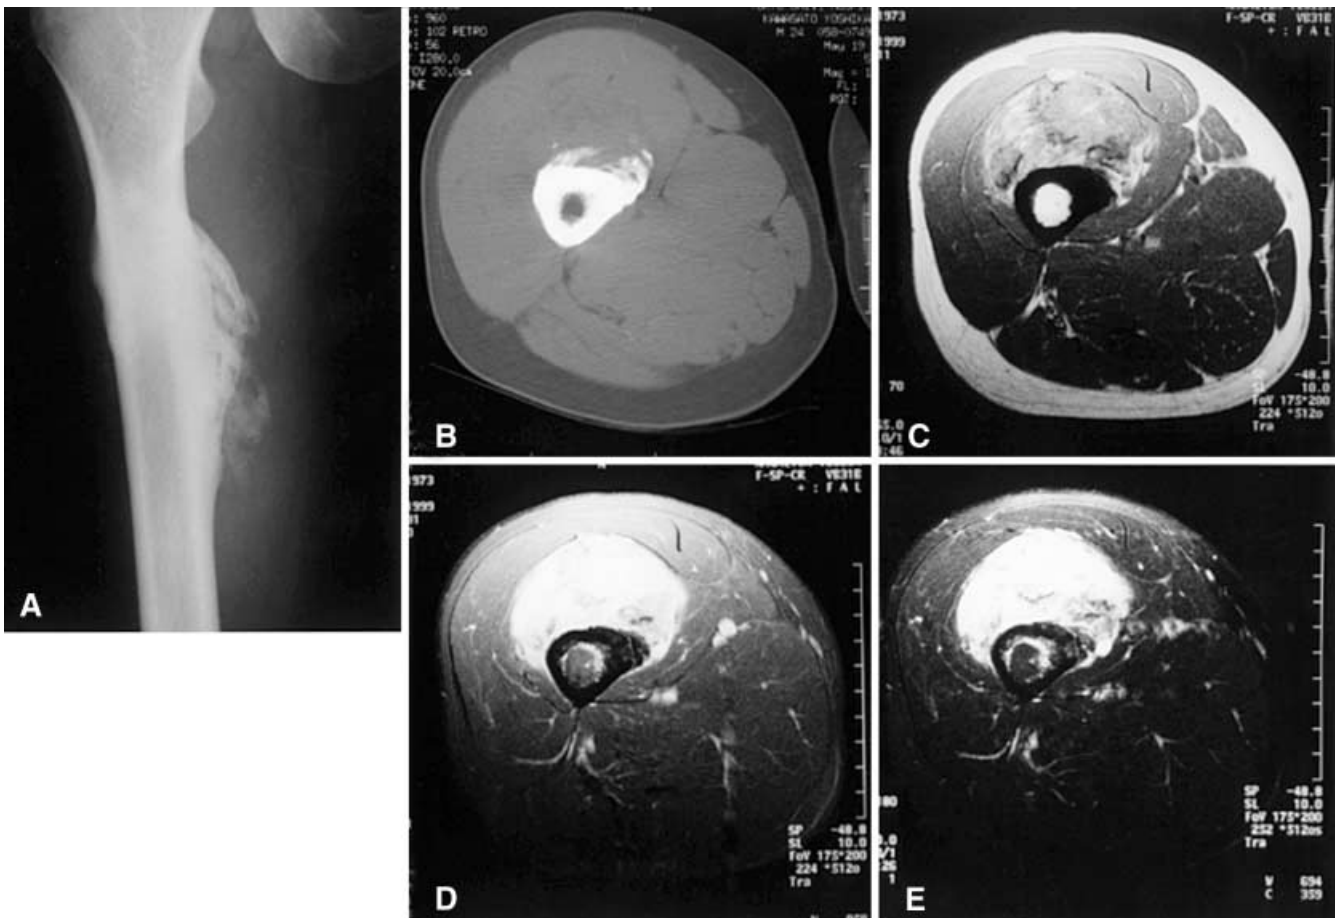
A Plain radiograph shows prominent periosteal new bone formation chiefly on the medial surface of the right femur. Thickening of the lateral cortex is also noted. B CT of the right thigh. Extra-osseous bone formation, probably periosteal, is seen in addition to thickening of the medial and lateral cortex. C T1-weighted MRI shows that the soft-tissue tumour covered two-thirds of the circumference of the femur. The tumour consists of a high signal intensity area and an iso-signal intensity area intermingled with each other. Thickening of the lateral and medial cortex is seen on this image, although the extra-osseous new bone formation that can be seen on CT (B) is not detectable. D T1-weighted MRI with gadolinium diethylene triamine penta-acetic acid (Gd-DTPA) enhancement shows that the tumour is strongly enhanced. E T2-weighted MRI with fat suppression signal shows some low signal intensity area which reflects the extra-osseous bone formation seen on CT (B)
